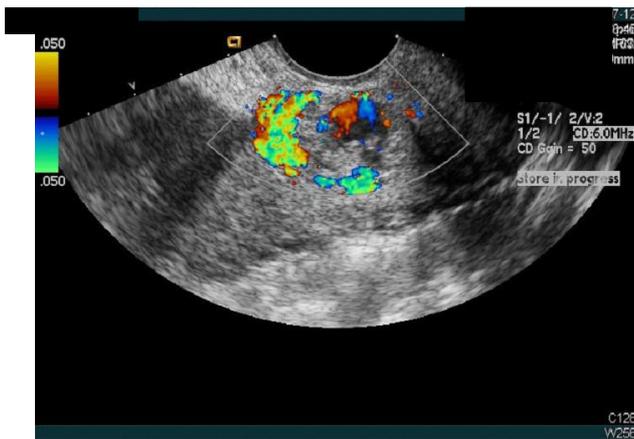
Doppler ultrasonography shows increased A-V malformation.
